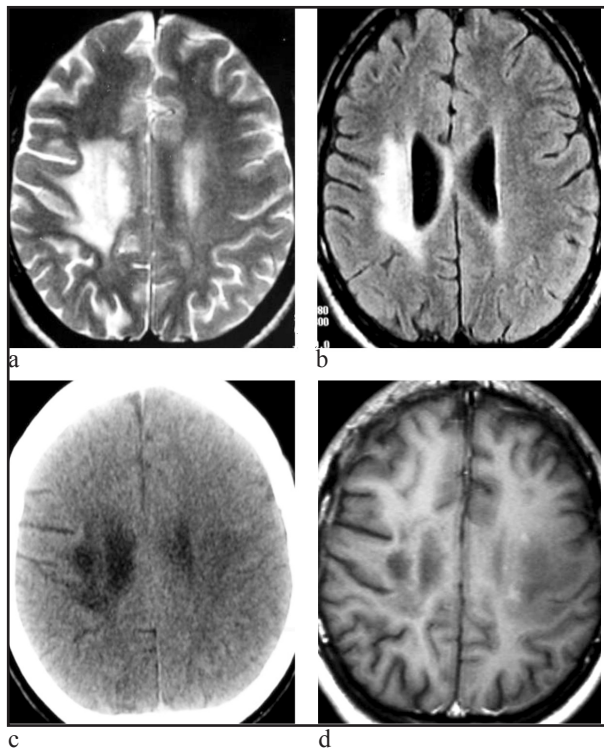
a. Axial T2-weighted image revealed a mass in the right semioval centre with mediocre edema. b. Axial T1-weighted image showed important restriction of the damage. c. Axial CT image showed hypointense lesion left respectively with the first lesion d. The MRI confirmed a second tumefactive lesion in opposite hemisphere, which showed spotted enhancement, while the first lesion did not show any enhancement.
